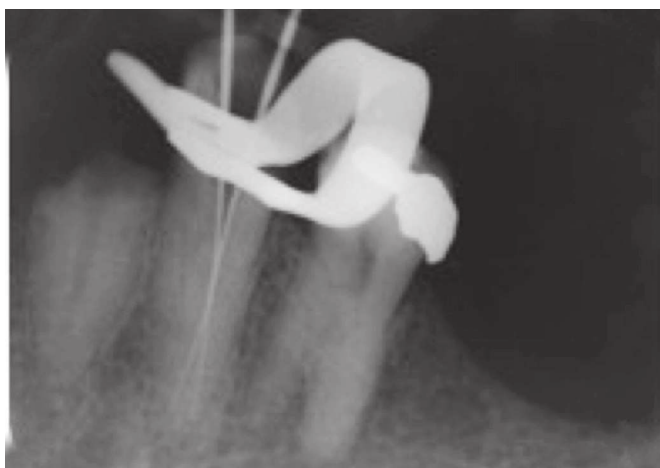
Radiographs used to determine the working length.
